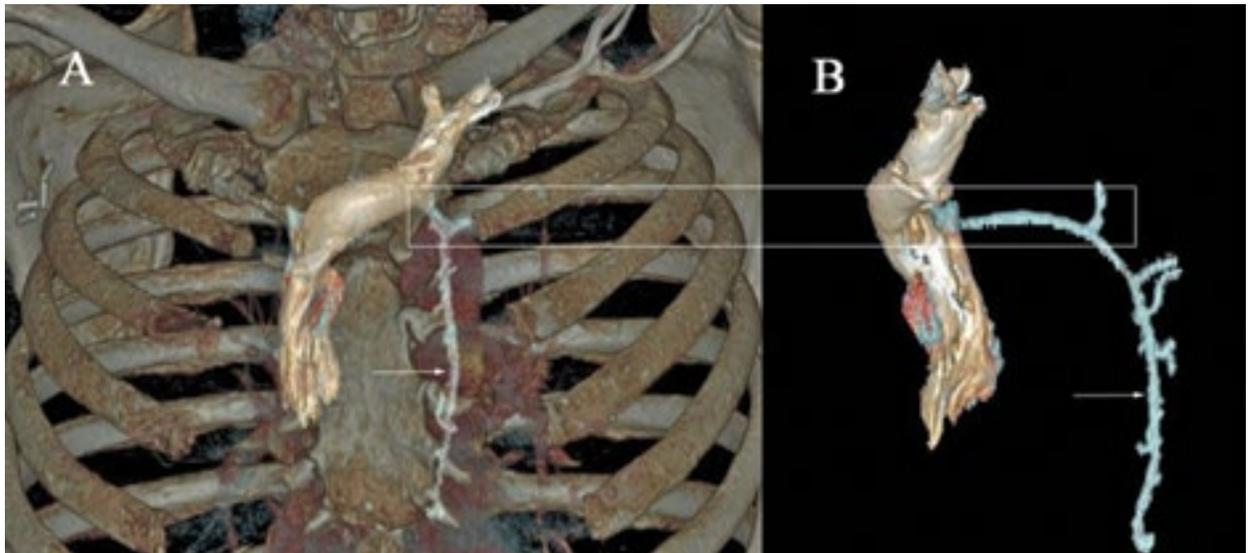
A three-dimensional (3D) computed tomography reconstruction (venous phase) of left superior intercostal vein (SICV) topography (arrow) and the venous junction at the inferior aspect of a curve in the left brachiocephalic vein (rectangular box): A. The left SICV: an anteroposterior (AP) view suggesting a straight vertical course of the vessel (a reconstructed image shown in relation to the bony structures of the chest; B. The left SICV: a lateral view showing the actual arching of the vessel, which curves around the aorta
